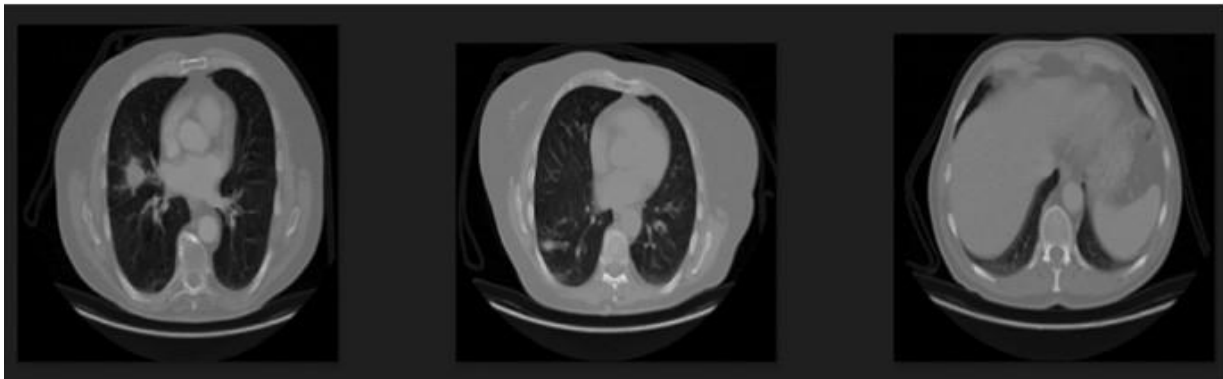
Sample CT image.
